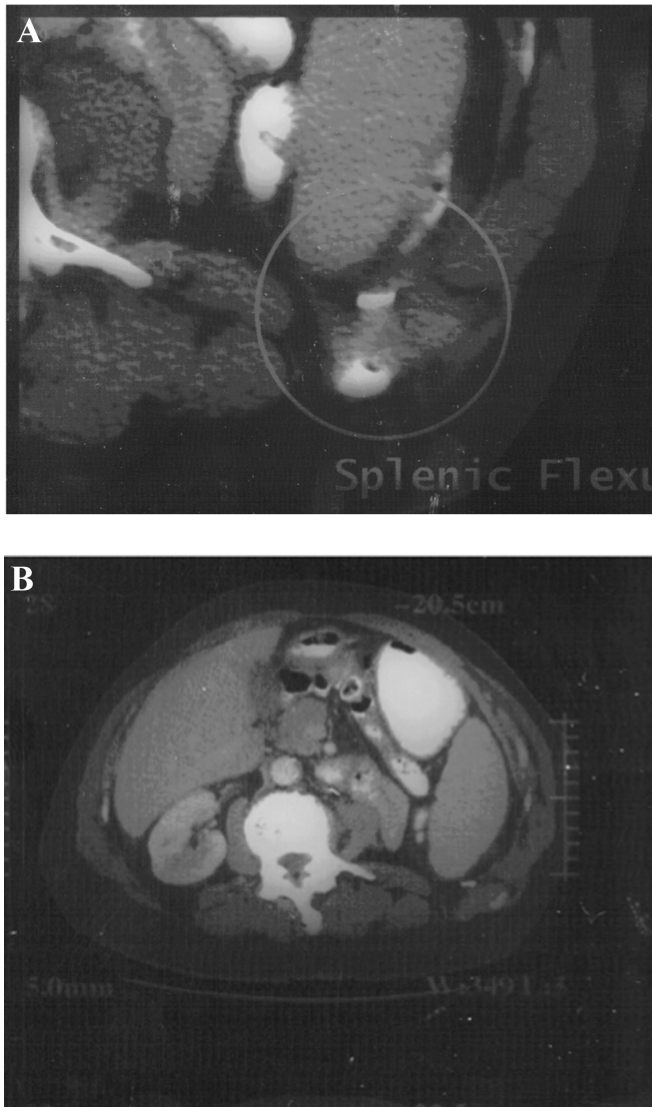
CT scans showing herniation of the splenic flexure of the colon (circle) through the left lumbar hernia.
